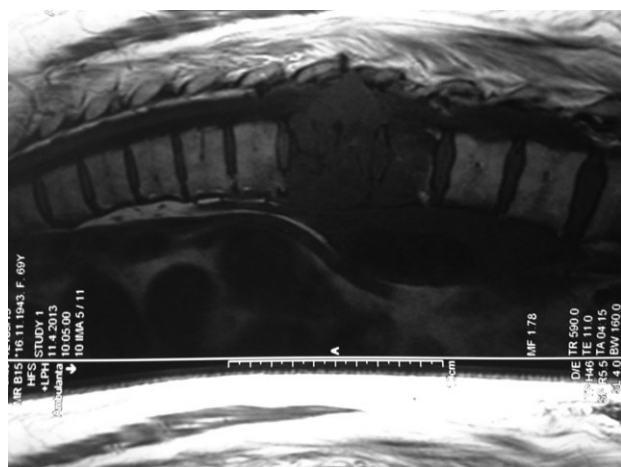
Contrast-enhanced MRI scan of the spine showing tissue/fluid dorsal paravertebral mass with the spread in the caudal third of the thoracic spine and the thoracolumbal transition. Destruction of Th VII and Th IX vertebrae and infiltration of the canal vertebralis caused by tumorous mass is visible on the photograph.
